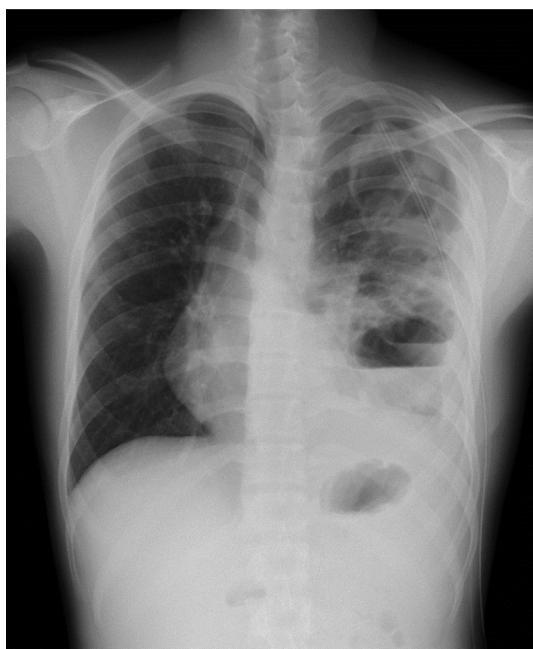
A chest X-ray obtained upon admission to the local hospital. The image shows left pneumothorax, pleural effusion, and multiple cavities.
